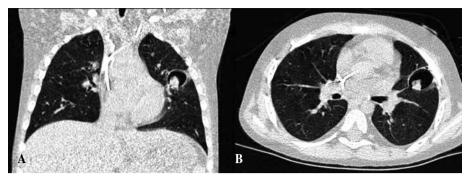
Pulmonary aspergilloma. Axial (A) and coronal (B) pulmonary CT-scan cuts demonstrating a cavitated lesion in the left pulmonary lingula, with presence of a fungal mass inside.
